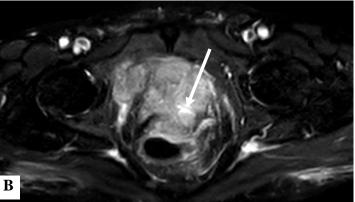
Axial MRI T2 weighted images and diffusion weighted images preradiation in a case of metastatic hormonesensitive prostate cancer.
